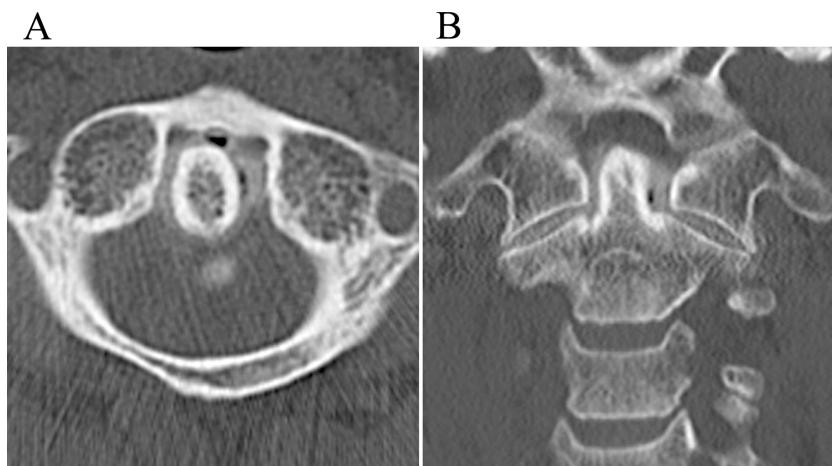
A and B, Computed tomograms after arthrography demonstrate a continuously spreading contrast medium into both sides of the lateral atlantoaxial and atlantodental joints and into the mass around the odontoid process.
